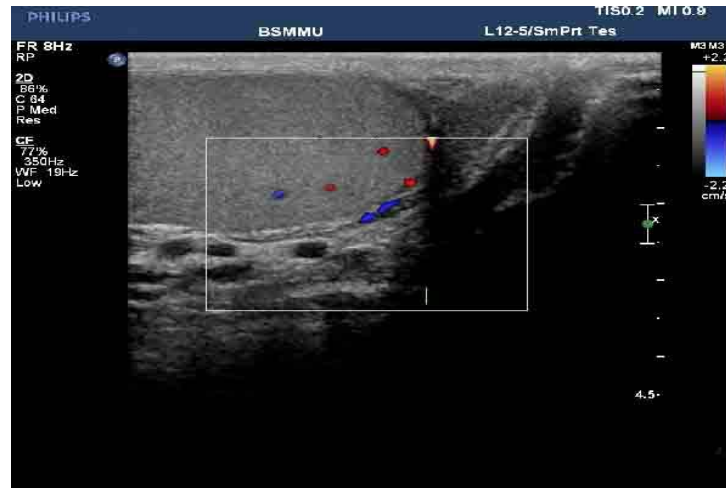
Normal Testis-Color Doppler scan showing echogenicity & vascularity of normal testis.
